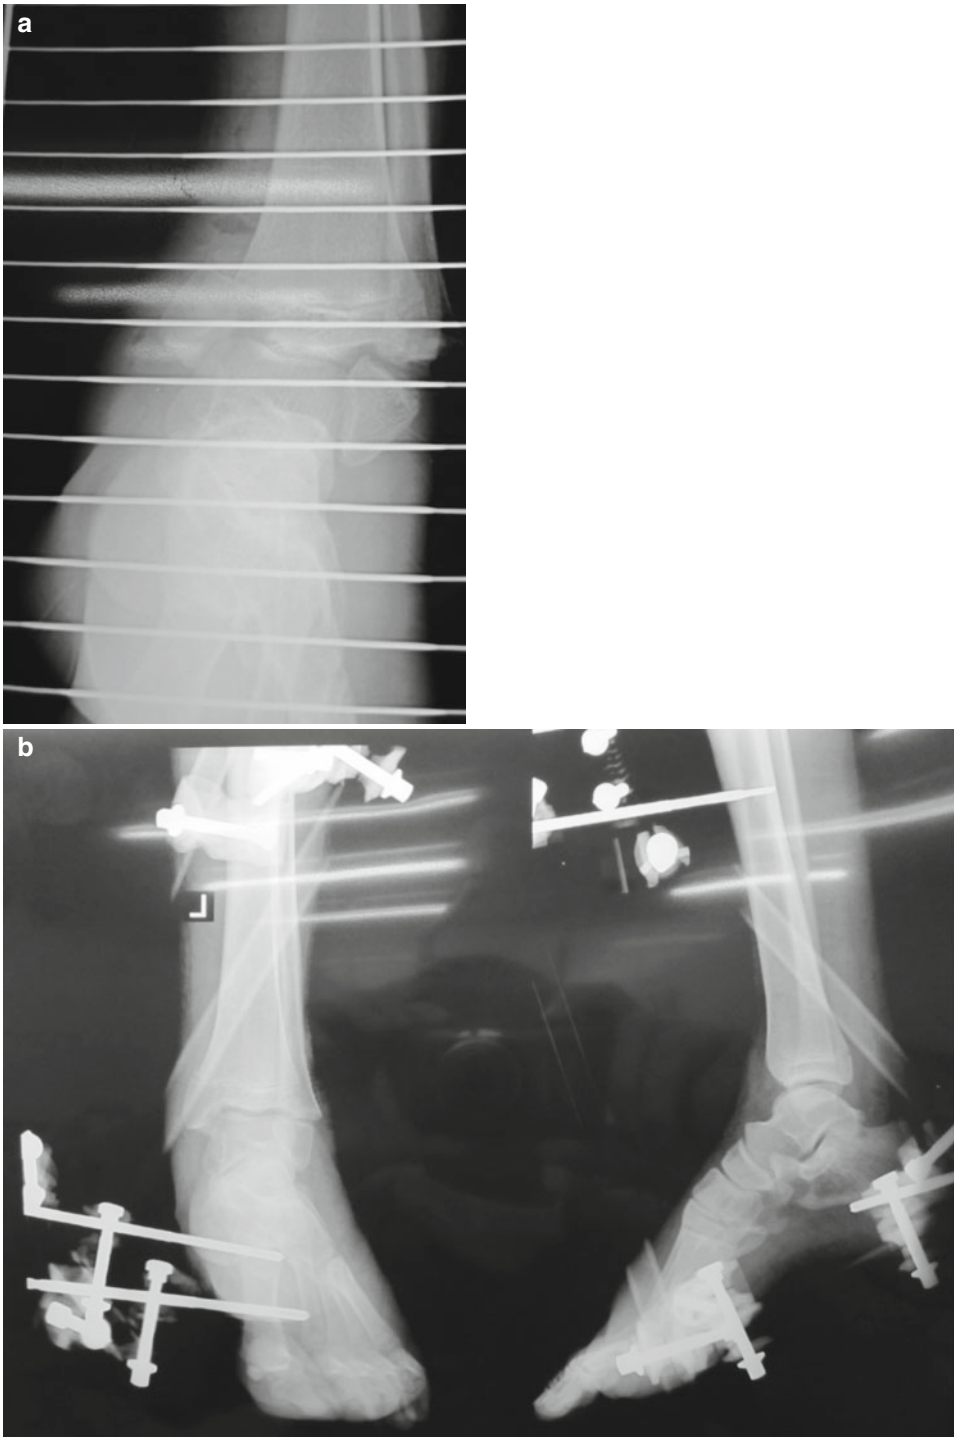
(a) A bimalleolar displaced ankle fracture and (b) AP and lateral X-ray showing fracture reduced indirectly and stabilised with an external fixation
